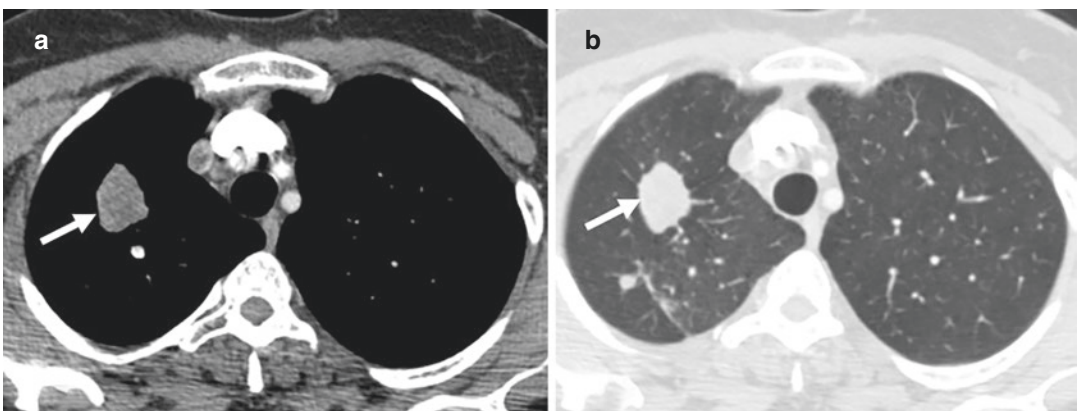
Tuberculoma in a 42-year-old woman. Axial contrast-enhanced CT images taken in (a) soft tissue and (b) lung window settings show a tuberculoma of the right upper lobe (arrows)
